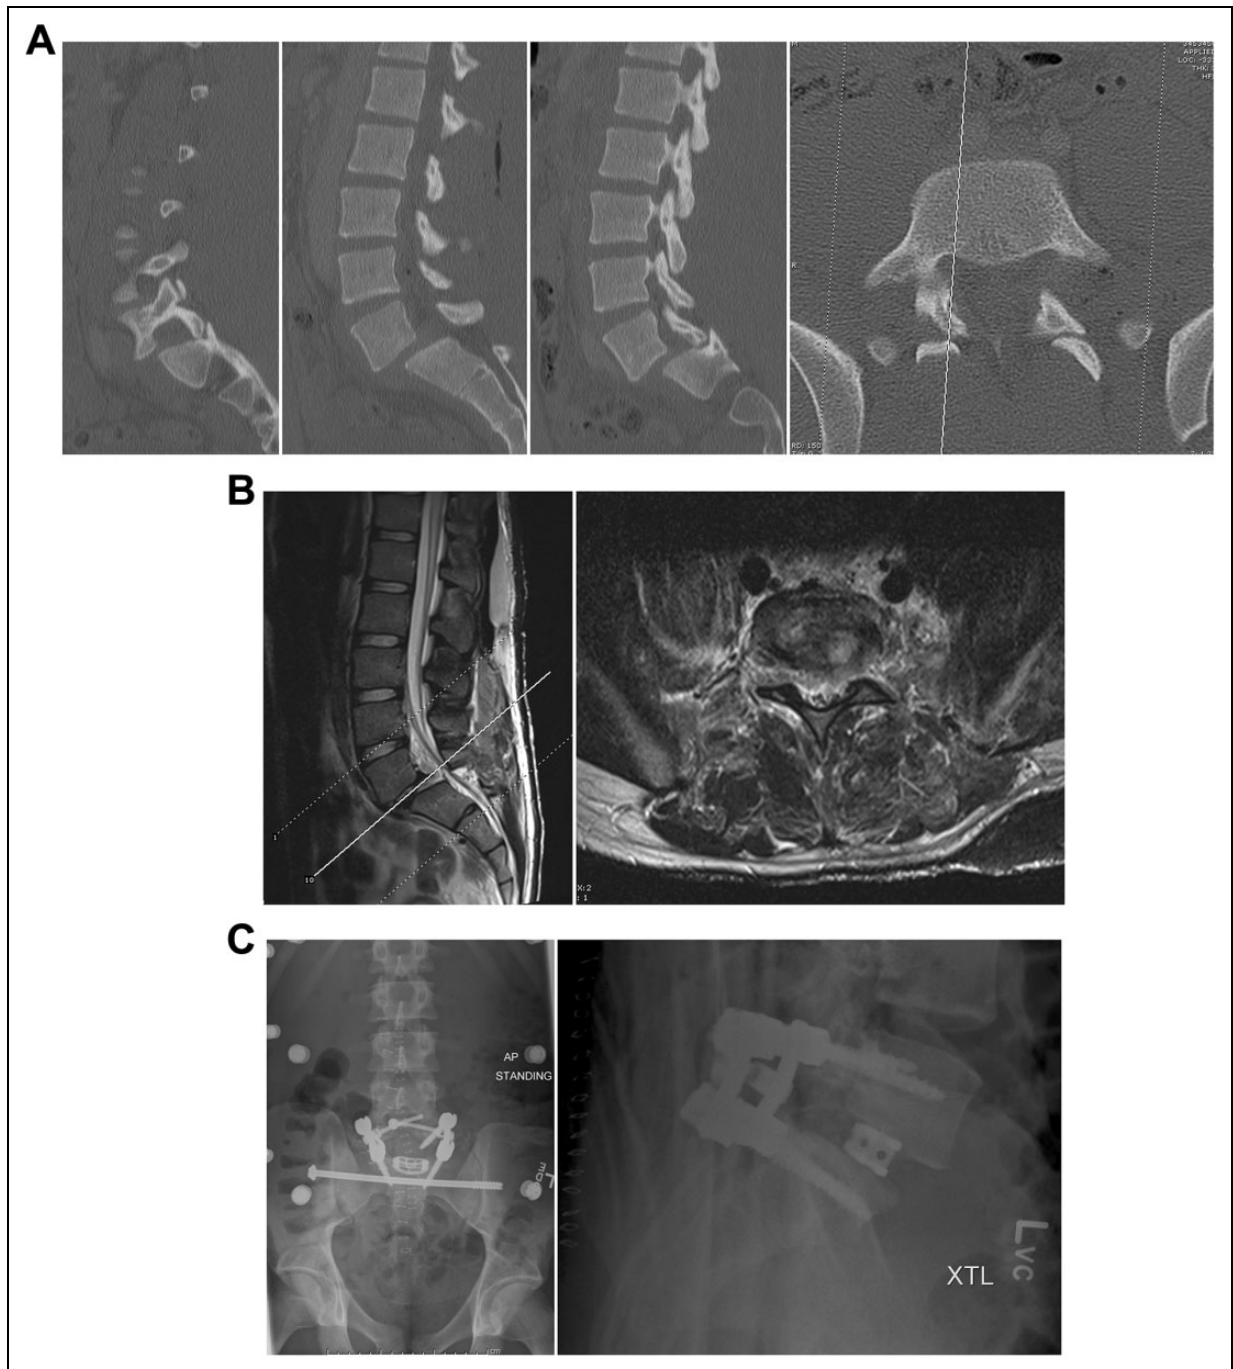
Patient 2 was a 19-year-old male involved in a road traffic accident who was neurologically intact with associated left scapula and right sacral fracture. (A) CT image showing L5-S1 bilateral facet dislocation (Dimar classification Type 1) with grade 3 anterior listhesis. (B) Disc injury seen on T2-weighted MRI scan. (C) Interbody fusion with supplemental posterior instrumentation and fusion was performed at L5-S1. On last follow-up at 1 year post injury, patient was ambulatory without complaints of pain and neurologic deficits, and had documented fusion.
